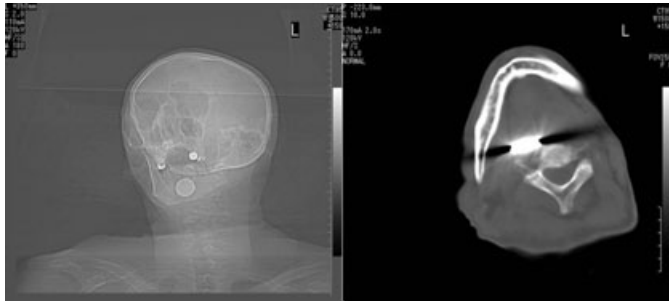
A case of foreign bodies in the pharynx and larynx. A 74-year-old man was found at home about 5 days after death. No foul play was suspected, so police at first determined that a forensic autopsy was not necessary. However, our computed tomography scan showed a coin-like shadowing in the pharynx. A forensic autopsy was then ordered, but the autopsy could not confirm the cause of death.
